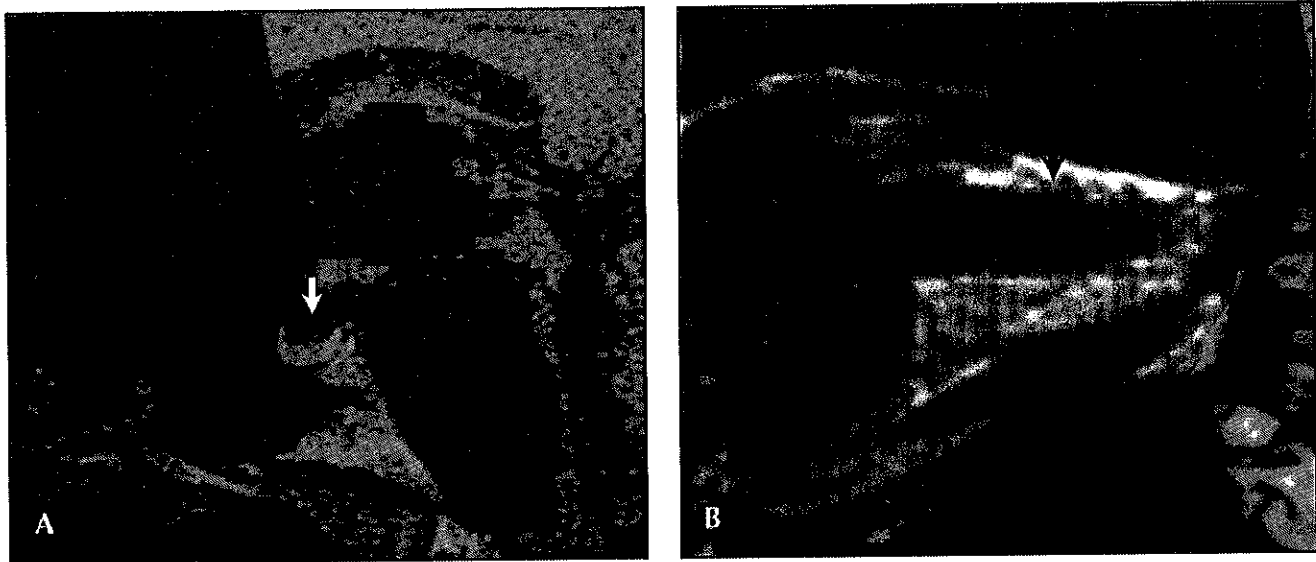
MRI of the patient in Figure 1. A, A partially empty sella (arrow). B, The sagittal view of the orbit reveals distention of the optic nerve sheath (arrow), flattening of the posterior sclera, and protrusion of the optic nerve papilla into the globe.
